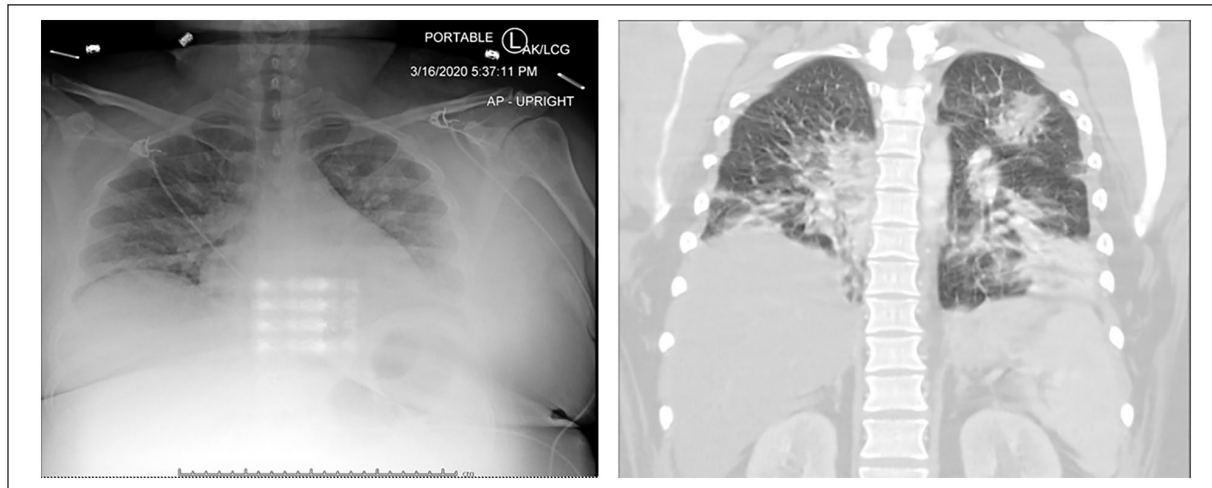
Left: chest x-ray of patient 1 with hazy opacities of the left lung base. Right: CT scan of patient 1 with diffuse ground glass, patchy opacities.
